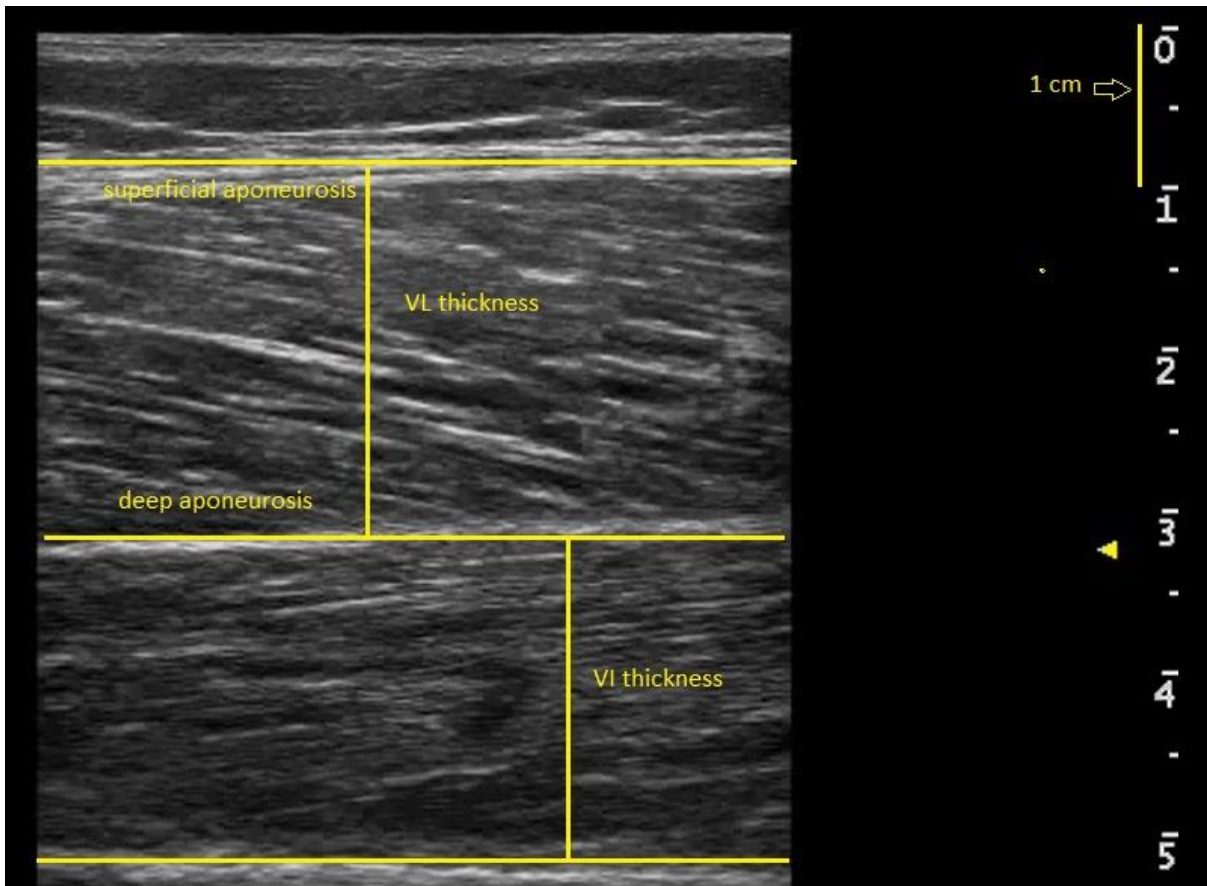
Measurement of Vastus lateralis thickness using sagittal plane B-mode ultrasound scans. Scan was obtained from a participant of the work described in the current thesis.
